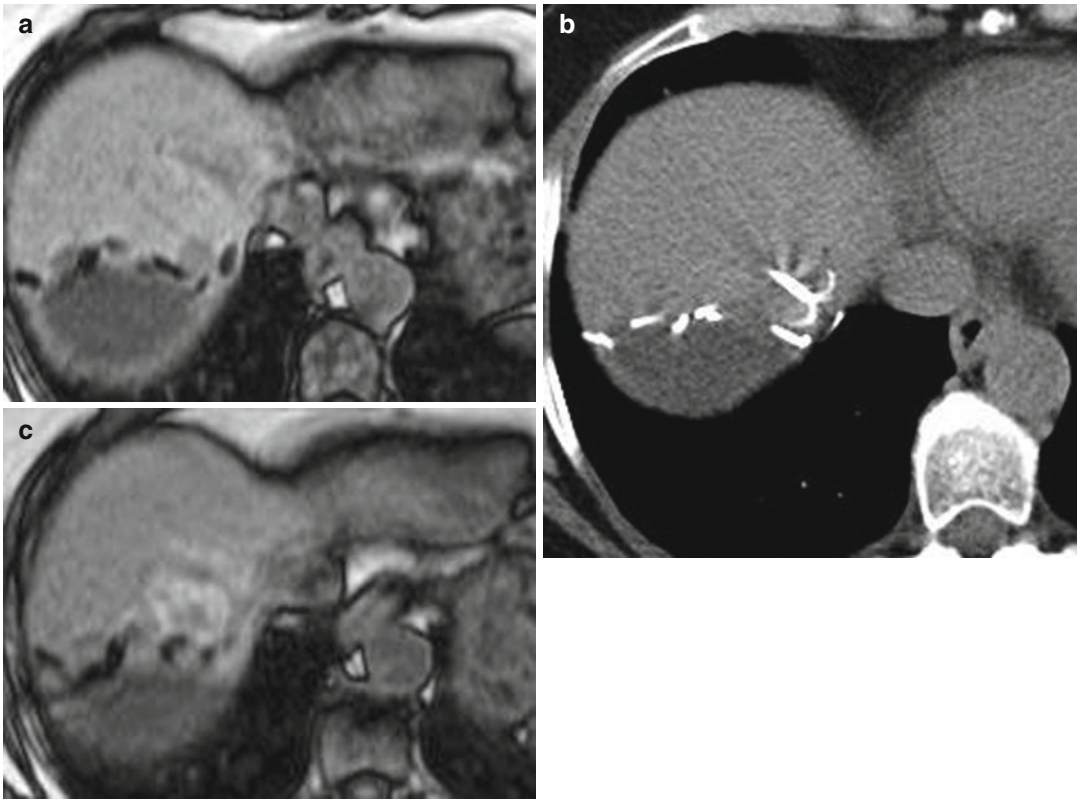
MR imaging prior and post RF-ablation of residual metastatic tumor 9 months after metastasectomy: T1-weighted opposed phase image demonstrates residual tumor adjacent to the resected area (a). Unenhanced CT
